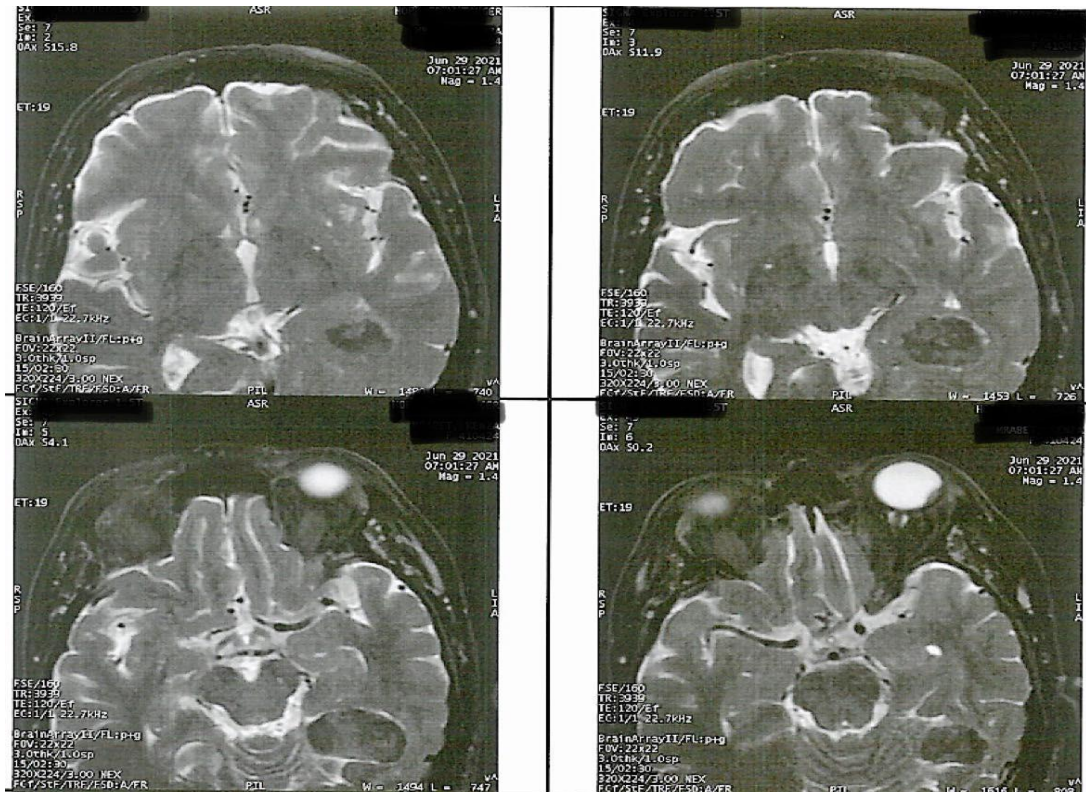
Brain MRI showing a left temporal occipital meningioma hypointense on T1
